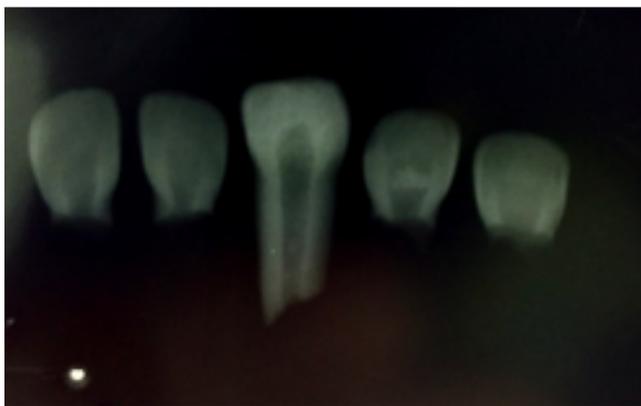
Radiographic image showing reduced radio-density of enamel & dentin of rickets affected teeth compared to the normal unaffected tooth (middle tooth)
